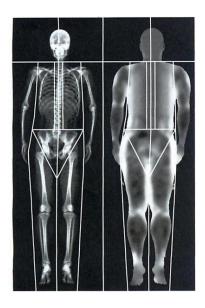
Whole body dual energy x-ray absorptiometry image
